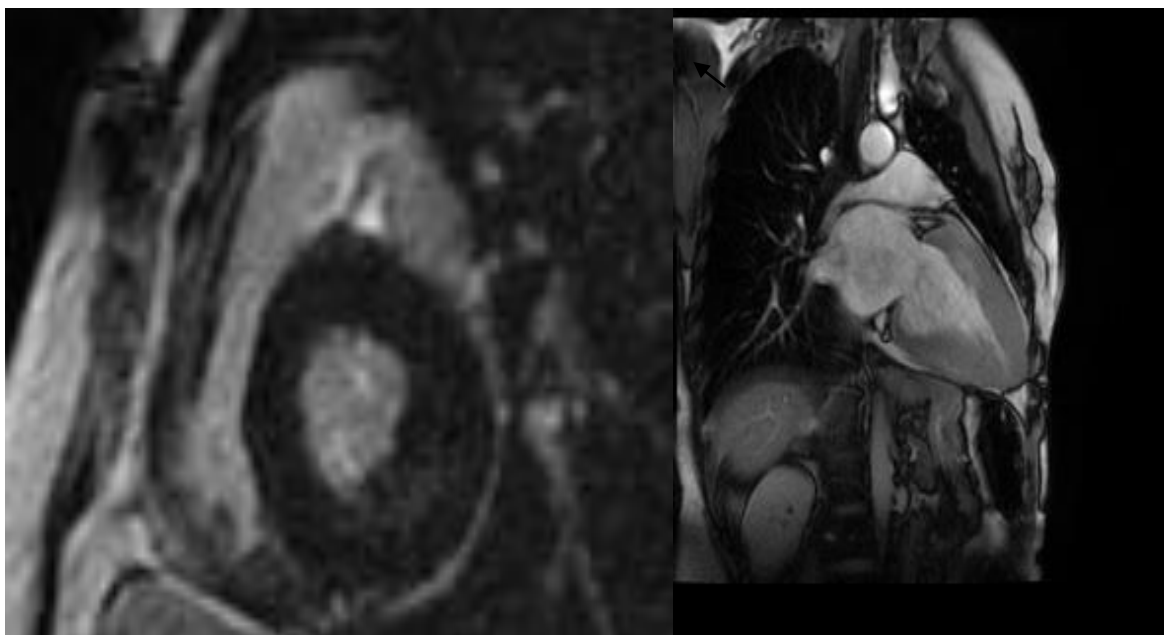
Cardiac MRI of DN, 50 years old
